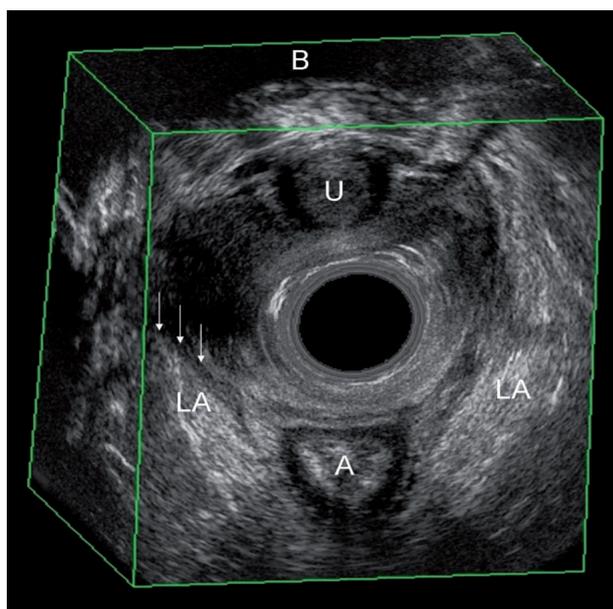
Endovaginal ultrasound with rotating probe, showing a damage of levator ani (LA) on the right side (arrows).
